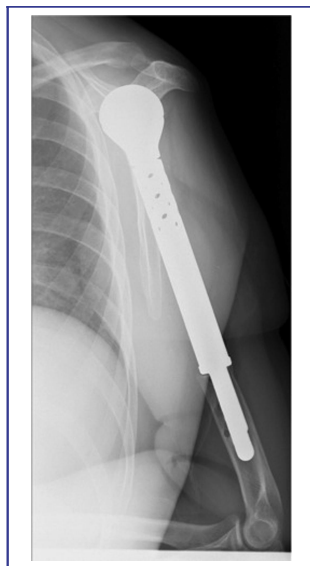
Post-operative X-ray imaging of the right proximal-humerus tumoral prosthesis. After tumor removal, a prosthesis was implanted into the right humerus of the patient in March 2010.
